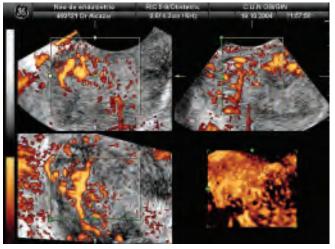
Three-dimensional power Doppler depiction of vascular architecture in a case of endometrial cancer. Chaotic pattern is clearly seen
